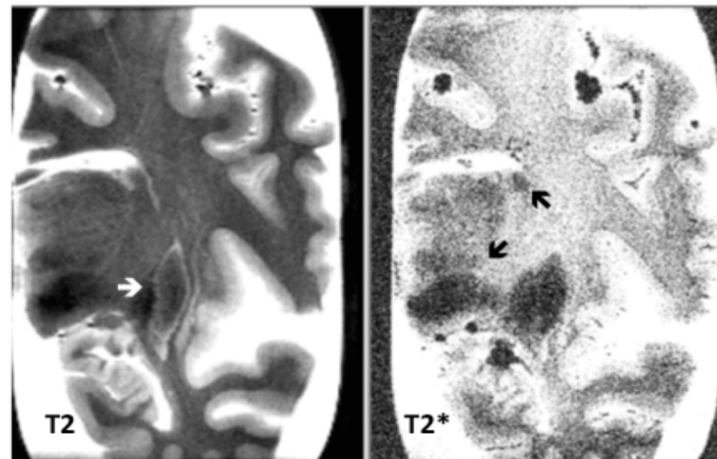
7.0-tesla MRI of a hemispheric section of a brain with amyotrophic lateral sclerosis. A putaminal infarct is present on the T2 sequence (white arrow) with iron load on the T2* sequence. Iron accumulation is present in the caudate and subthalamic nuclei on T2* sequence (black arrows) (INSERM 1171, France).
